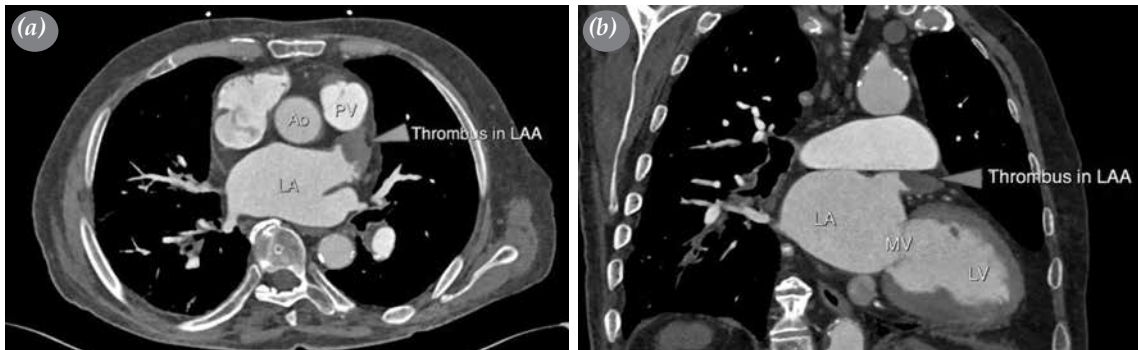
(a, b) Contrast-enhanced computed tomography images showing a thrombus in left atrial appendix.
